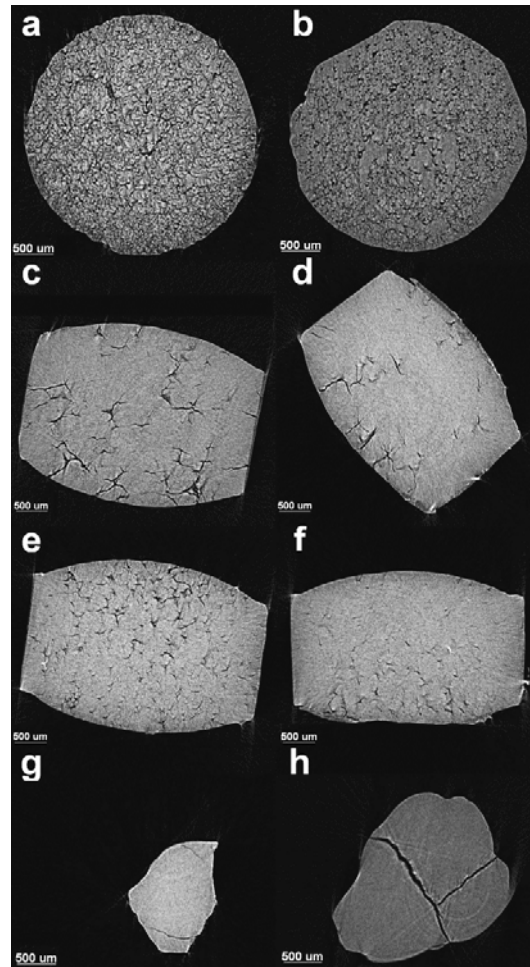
Representative  $\mu$ CT images (slices) of glyceride matrices obtained by different technologies (A) GB EX; (B) GPS EX; (C) GB GMT L; (D) GPS GMT L; (E) GB GMT S; (F) GPS GMT S; (G) GB PR (fragment); (H) GPS PR. GMT L were compressed from larger granules ( $0.500 \leq d \leq 0.750$  mm) while GMT S were compressed from smaller granules ( $0.150 \leq d \leq 0.250$  mm)
